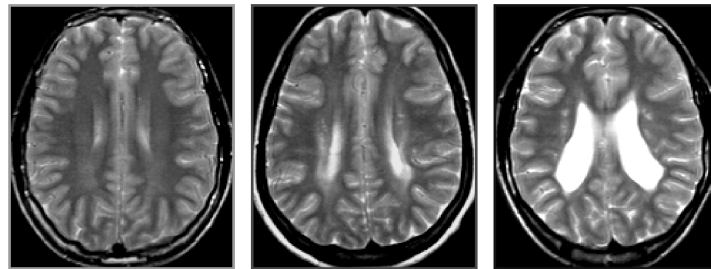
Structural MR images for the representative participants RK (preterm without PVL, left), ST (preterm with mild PVL, middle) and SS (preterm with severe PVL, right panel).
